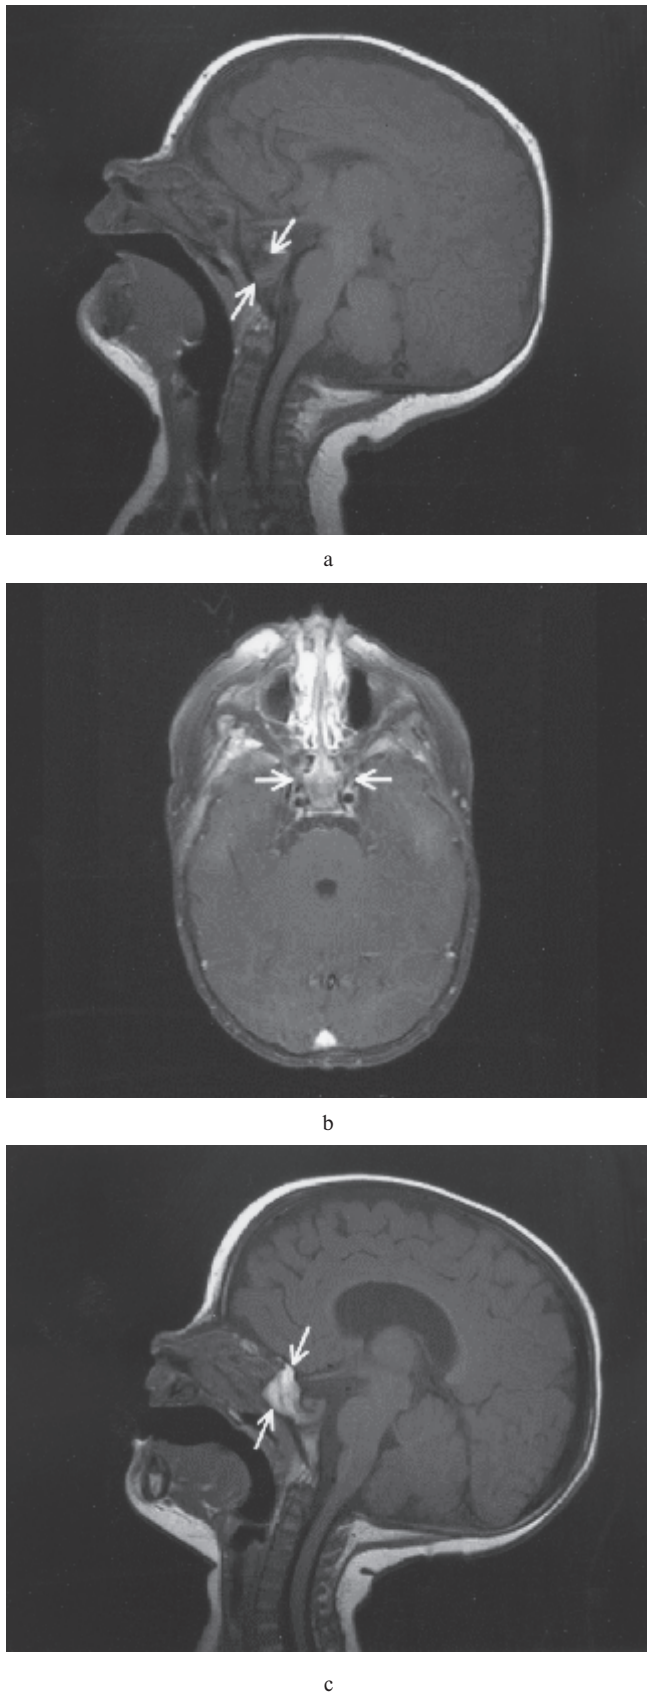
(a,b,c). Midsagittal (a,c) and axial (b) T1-weighted MR-images (650/30) showing bone marrow conversion of the sphenoid bone from red to fatty. Signal reveals (a) uniformly low signal intensity in a 3-months old female infant. Signal gradually changes from (b) mixed (8-months old boy) to (c) uniformly high signal intensity (11-months old girl) (arrows).
